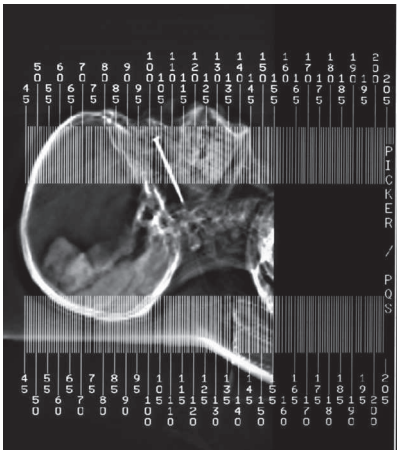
CT scan 'scout' image showing the location of the nail in its proximity to the posterior nasopharyngeal wall.
